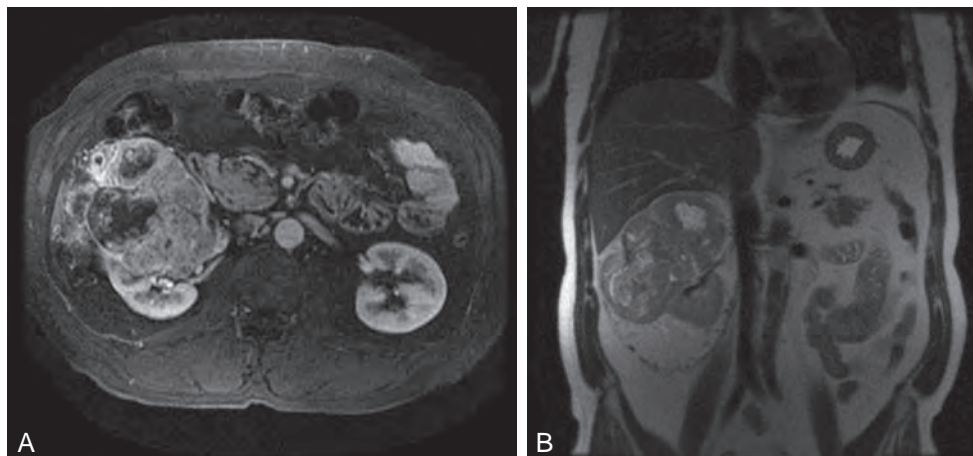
Axial (A) and coronal (B) magnetic resonance images of a right-sided renal mass.
